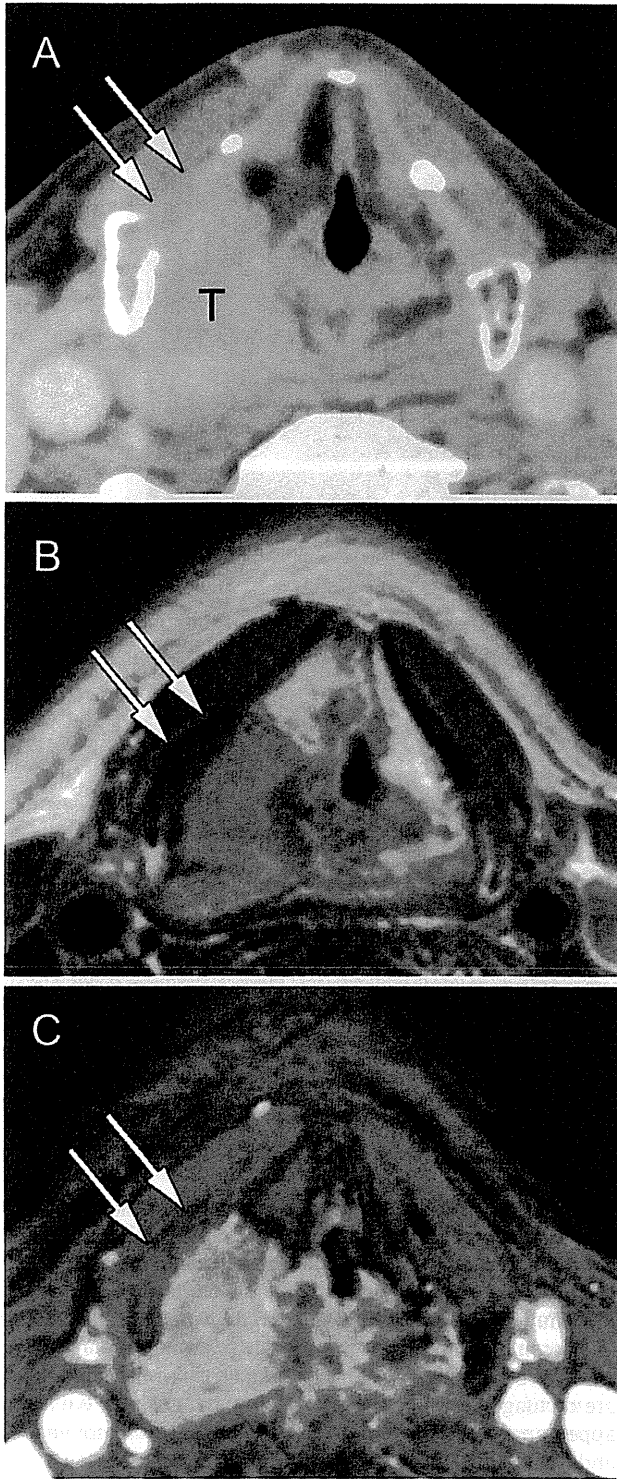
True negative finding for thyroid cartilage invasion by MR imaging in a 69-year-old man with hypopharyngeal cancer. (A) Axial contrast-enhanced CT image at the level of the false vocal cords shows tumor mass (T) arising from the right piriform sinus. The tumor is located adjacent to non-ossified cartilage of the right thyroid lamina, and the tumor and cartilage show similar CT values, making them almost indistinguishable (arrows). (B) T2-weighted MR image obtained at the same level shows a right-sided piriform sinus tumor with intermediate signal intensity. The adjacent right thyroid lamina can be differentiated by its low signal intensity (arrows). (C) Fat-suppressed contrast-enhanced T1-weighted image shows contrast enhancement of the tumor mass and poor enhancement of the thyroid lamina (arrows) relative to the adjacent tumor mass. Pathological findings confirmed that there was no tumor cell infiltration into the cartilage.
